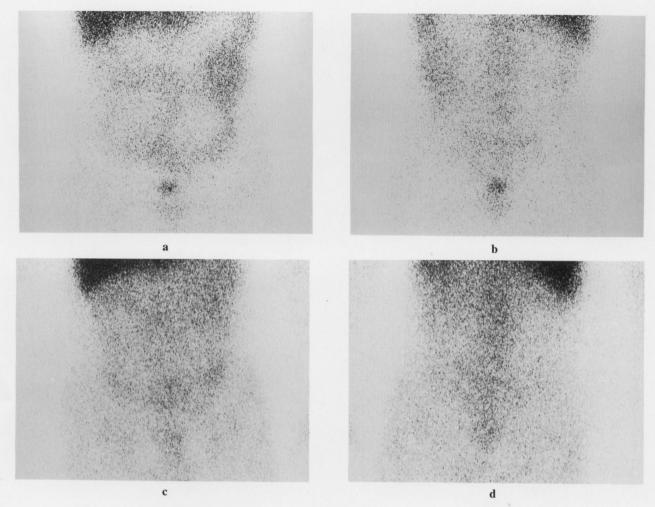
Ga-67 scintigraphy: Anterior (a) and posterior (b) scans taken three days after the injection of 111 MBq of Ga-67-citrate. The abnormal accumulation of Ga-67-citrate in the prostate was shown in both images. Follow-up study was taken 15 days after admittance (ten days after initiation of antibiotic therapy). At this time CRP lowered to 2 mg/dl (normal limit is below 0.4 mg/dl). The abnormal radionuclide accumulation disappeared in the follow-up study, 7 days after discharge (c: anterior, d: posterior).
